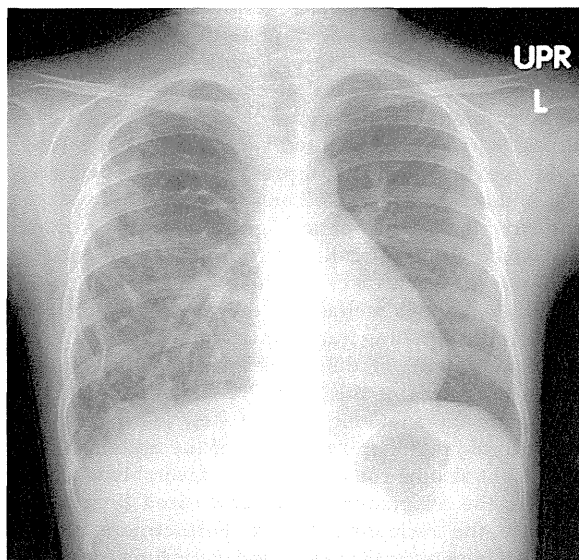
Chest radiography 6 months after living-donor right single-lobe lung transplantation. No severe compression of the implanted lungs was noted.
